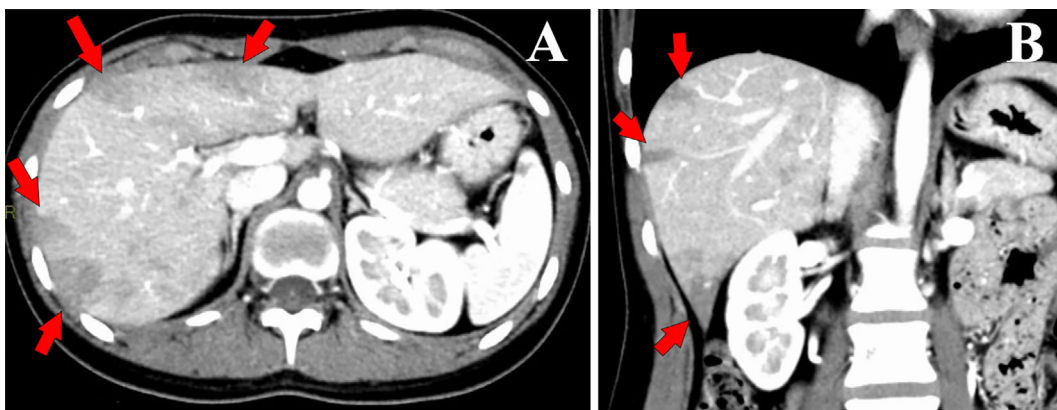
Multiple areas of poor contrast in the liver with irregular margins on contrast-enhanced computed tomography (indicated by red arrows). (A) Axial and (B) coronal views.
